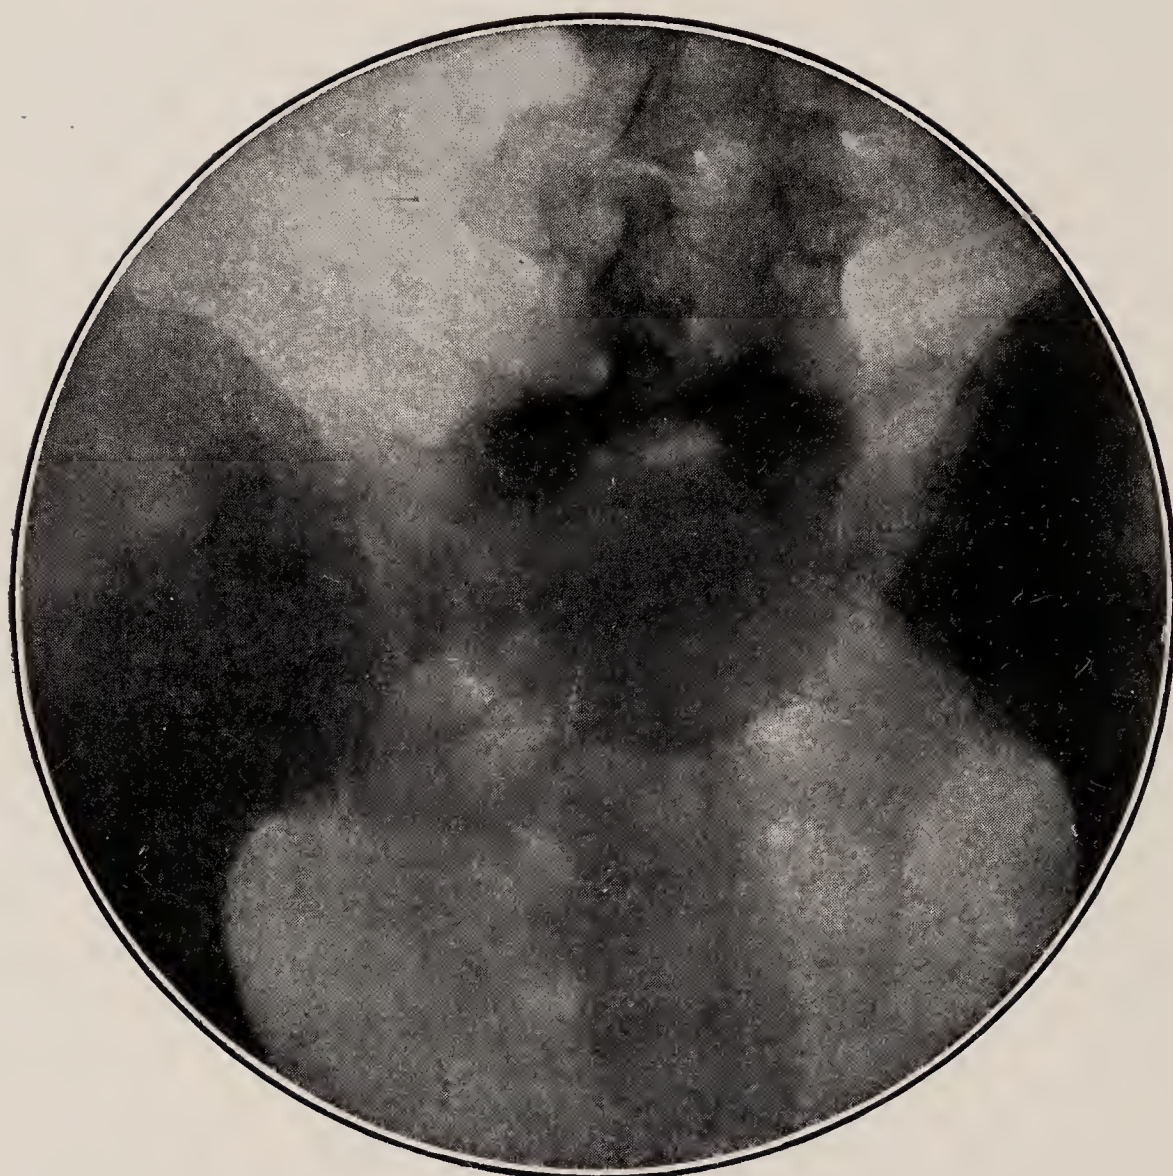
Spondylolisthesis—characteristic appearance of X-ray.
